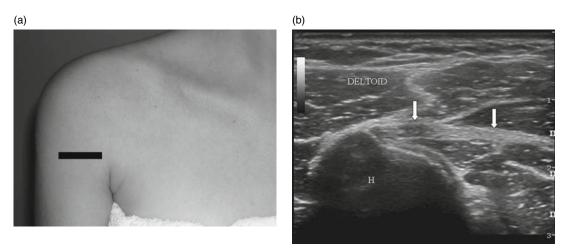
Pectoralis major: (a) transducer position and (b) corresponding ultrasound image of the longitudinal plane tendon at the humeral insertion. H, humerus.
